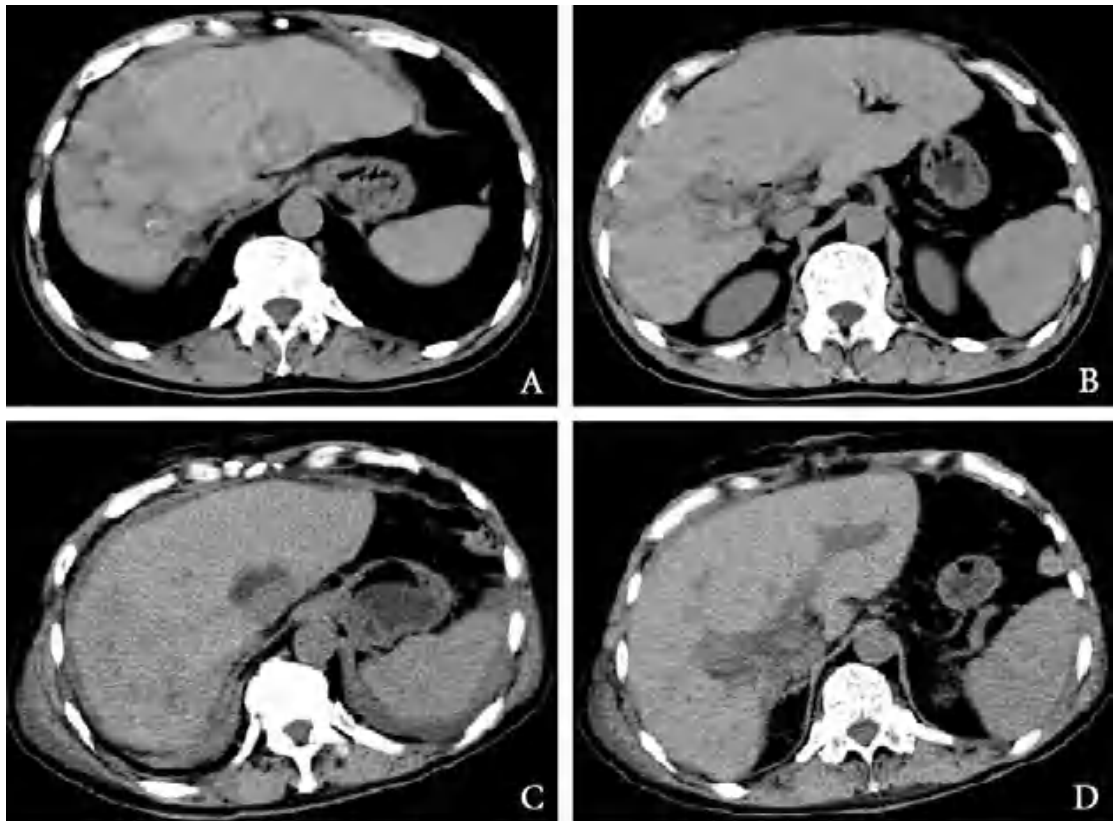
A、B: 激光碎石术前腹部 CT 显示大量结石位于双侧肝内胆管; C、D: 激光碎石术后腹部 CT 显示肝内胆管无结石
